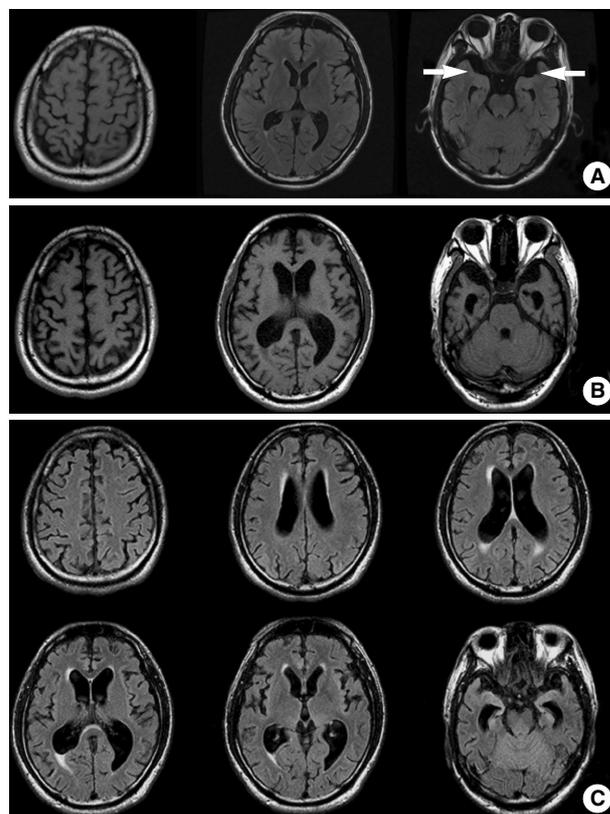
Progressive cortical atrophy seen on brain magnetic resonance imaging (MRI). (A) Axial T1-weighted image performed in 2006 shows diffuse cortical atrophy, particularly in bilateral medial temporal lobes (arrow), accompanied by secondary ventricular dilatation. (B) Follow-up MRI acquired in 2007 revealed progression of diffuse cortical atrophy. (C) Fluid attenuated inversion recovery (FLAIR) images of 2007 disclosed mild degree of high signal intensities in the periventricular white matter.
